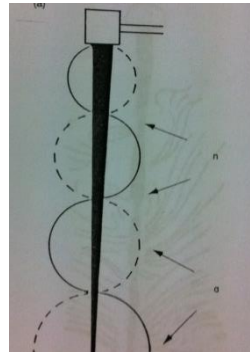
the transverse oscillation of ultrasonic file (83)
